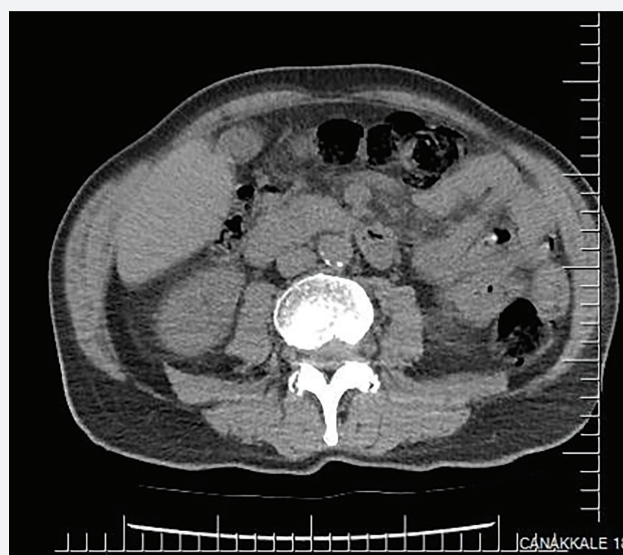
Normal pancreatic CT image at diagnosis
